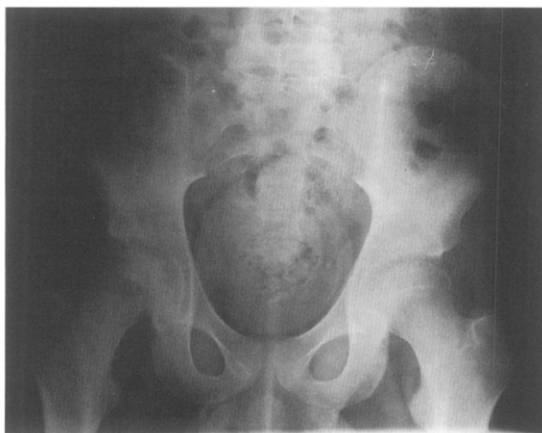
Radiograph of both hips showing demineralization in the region of the right femoral head.
